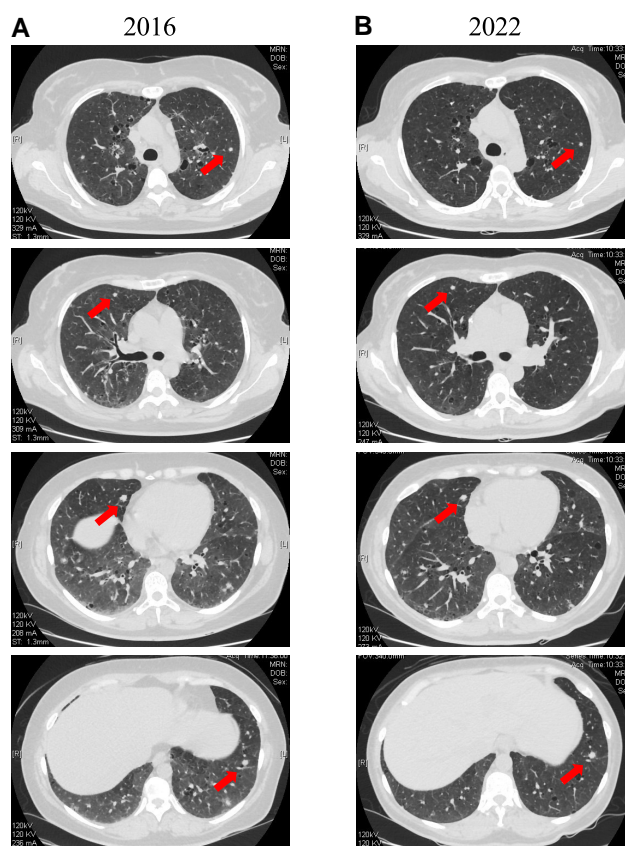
Comparison of chest CT scans. (A) Chest CT scan obtained in October 2016 before initiating metformin therapy. (B) Chest CT scan obtained in October 2022; that is, 5 years after starting metformin treatment. The size of the lung tumors (arrows) did not change significantly between 2016 and 2022. Abbreviations: CT, computed tomography.
